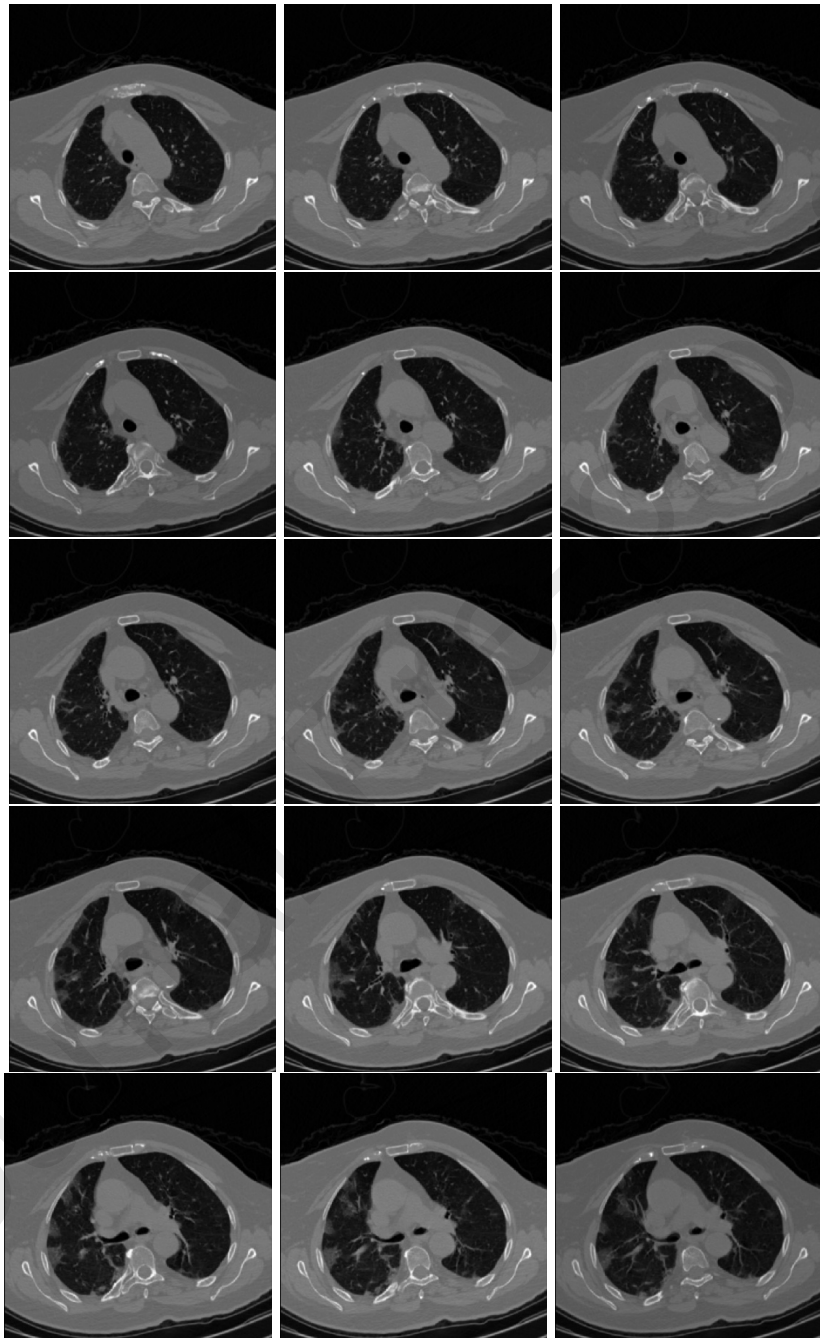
Slices from a COVID-19 CT scan in COV19-CT-DB
